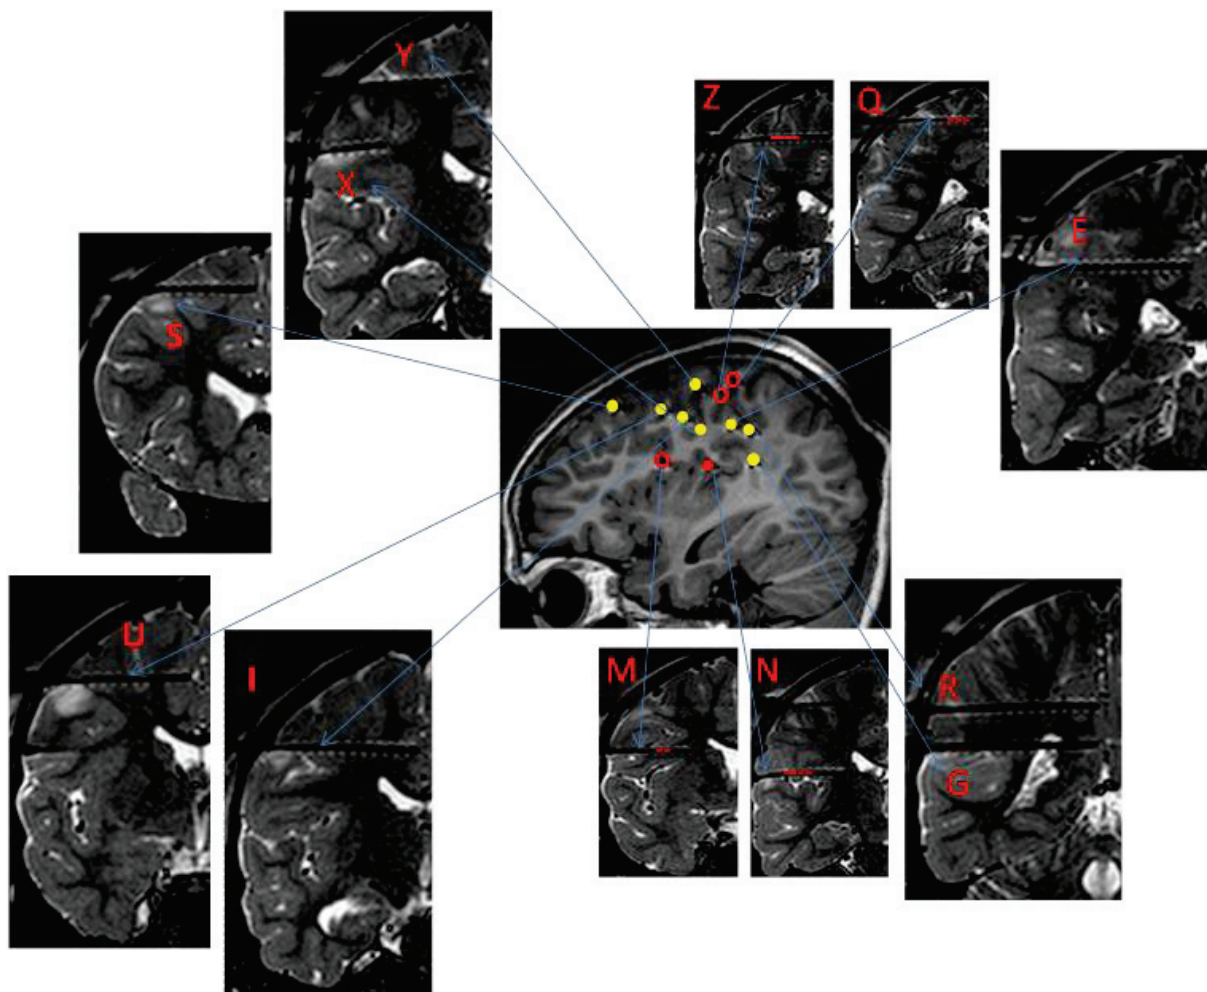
11: Patient 11 MRI with electrodes in place (right hemisphere). Central sagittal image: each insular electrode is represented by a unique colored solid circle; non-insular
